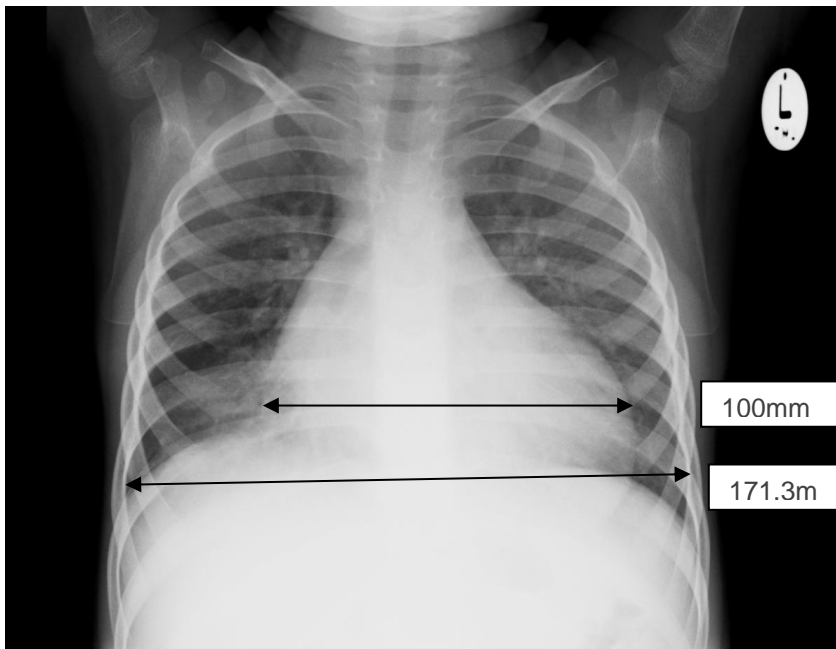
Chest X-ray showing enlarged heart in a child with HIV associated dilated cardiomyopathy
